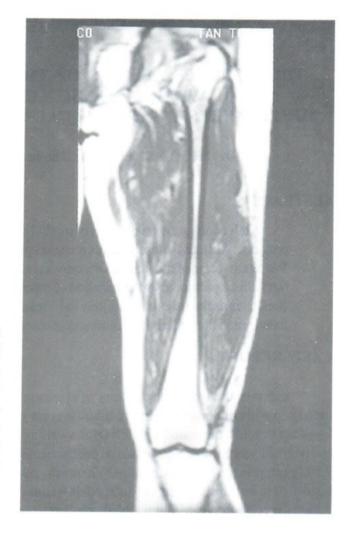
Coronal MR images of the thigh of the patient.
